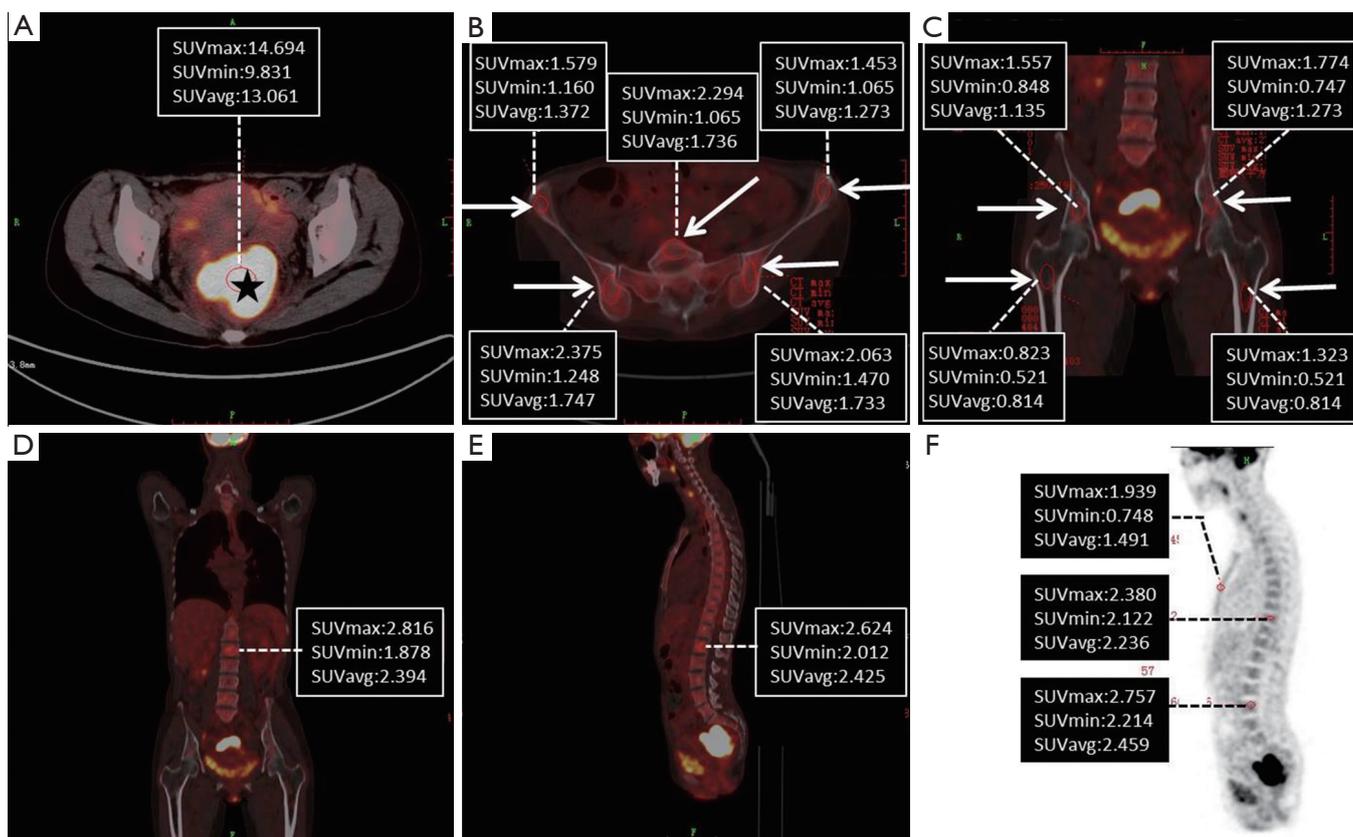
^{18}F -FDG PET/CT fusion images for a 45-year-old female patient with rectal cancer. (A) Axial ^{18}F -FDG PET/CT fusion image demonstrates a primary tumour with high uptake with a SUVmax of 14.694 in the rectum (star); (B) axial ^{18}F -FDG PET/CT fusion image reveals multiple patchy slight uptake in the sacrum and bilateral ilia (arrows) with a SUVmax lower than 2.4; (C) coronal ^{18}F -FDG PET/CT fusion image reveals multiple patchy slight uptakes in the bilateral ilia and femurs (arrows) with a SUVmax lower than 1.8; (D) coronal ^{18}F -FDG PET/CT fusion image reveals multiple patchy slight uptakes in the vertebrae; (E) sagittal ^{18}F -FDG PET/CT fusion image reveals multiple patchy slight uptakes in vertebrae; (F) sagittal ^{18}F -FDG PET image reveals diffused slight uptakes in the vertebrae and sternum with a SUVmax lower than 2.8.
